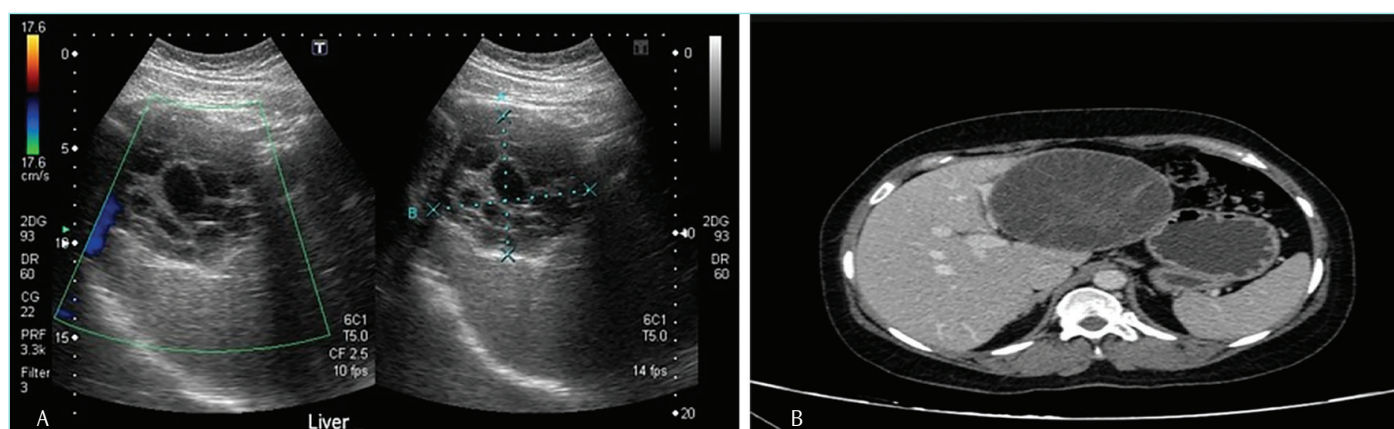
Imaging of hepatic hydatid cysts. (A) Abdominal ultrasonography demonstrates a cystic lesion with daughter cysts in the right hepatic lobe. (B) Contrast-enhanced computed tomography demonstrates the same lesion with a well-defined cyst wall and internal septations.
